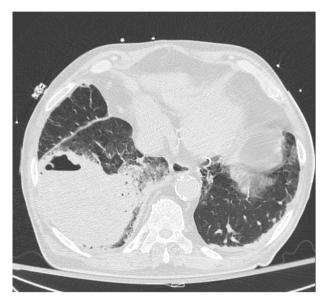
Thoracic CT-scan showing a massive right necrotic pneumonia.
